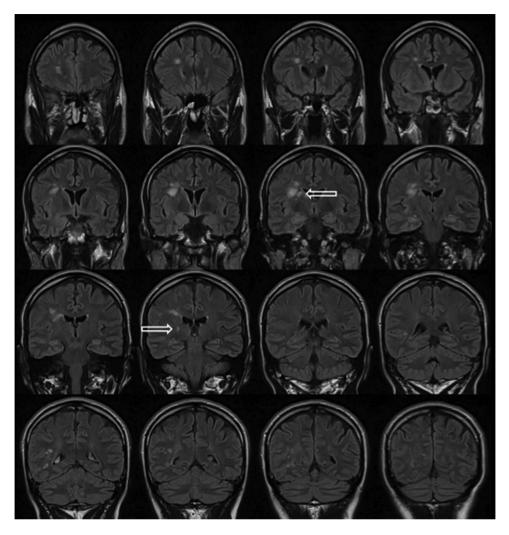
FLAIR images showing no evidence of infarcts in the cortical gray matter, basal ganglia and thalami. Signal hyperintensities are present in the white matter of the right cerebral hemisphere, anterior and posterior limb of the right internal capsule (arrows).
